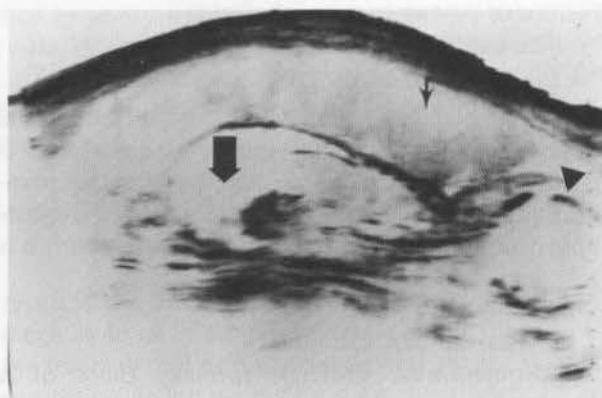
Sonogram showing fetal hydrops secondary to severe Rh sensitization. Note the thick placenta (arrow), the halo around the skull (arrowhead), and fetal ascites (broad arrow).
